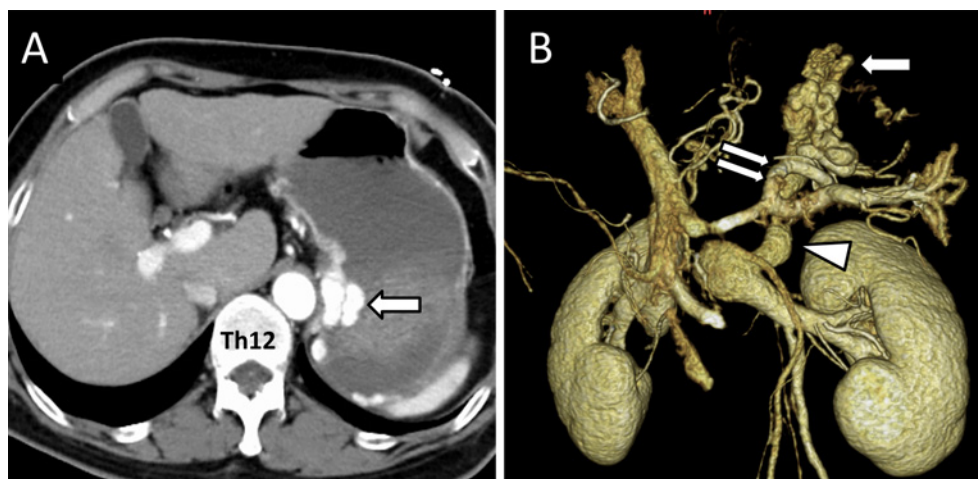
Contrast-enhanced CT at ER. A: Early phase of contrast-enhanced CT revealed large varices protruding into the gastric lumen (white arrow). There was no contrast extravasation suggestive of active bleeding. B: In 3D volume rendering images, gastric varices (white arrow) were found to receive blood from the posterior gastric vein (double white arrow) and drain to the inferior phrenic vein (arrowhead).
